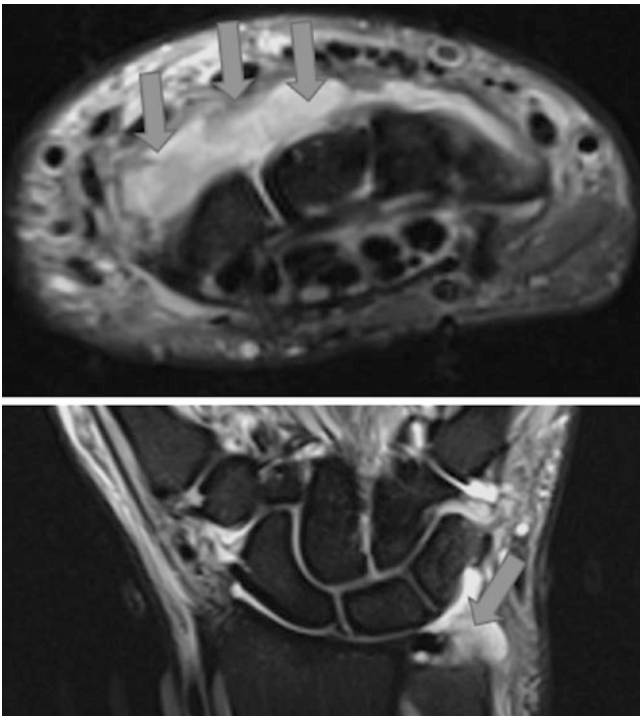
Axial and coronal fluid-sensitive MR images demonstrate joint effusion and evidence of synovitis (arrows) involving the distal radioulnar joints and midcarpal joints compatible with inflammatory arthropathy
